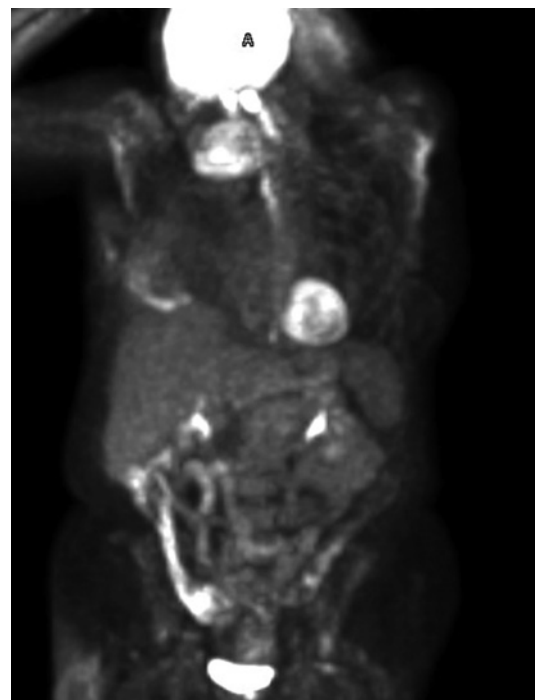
Staging scan from December 2022, ¹⁸F-FDG-PET scan of the patient showing region of ¹⁸F-FDG uptake in the right breast and axilla, minus left lung lesion. PET, positron emission tomography.
